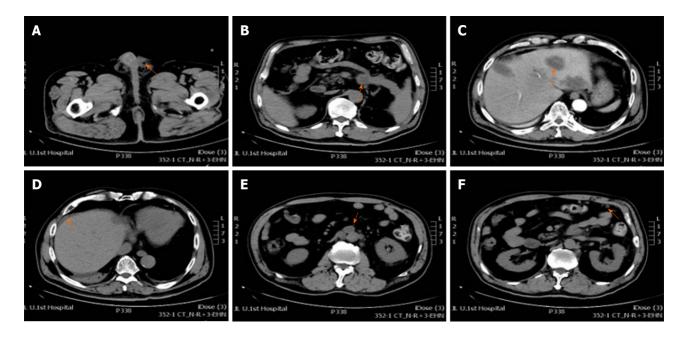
Postoperative abdominal radiologic findings. A: Abdominal computed tomography shows absence of the left testis (orange arrow indicating air density spot); B: Primary tumor can be seen in the tail of pancreas; C: Multiple hepatic metastasis; D: Abdominal cavity fluid; E: Retroperitoneal lymphadenopathy; F: Omentum metastasis (orange arrow indicates relevant lesions).
